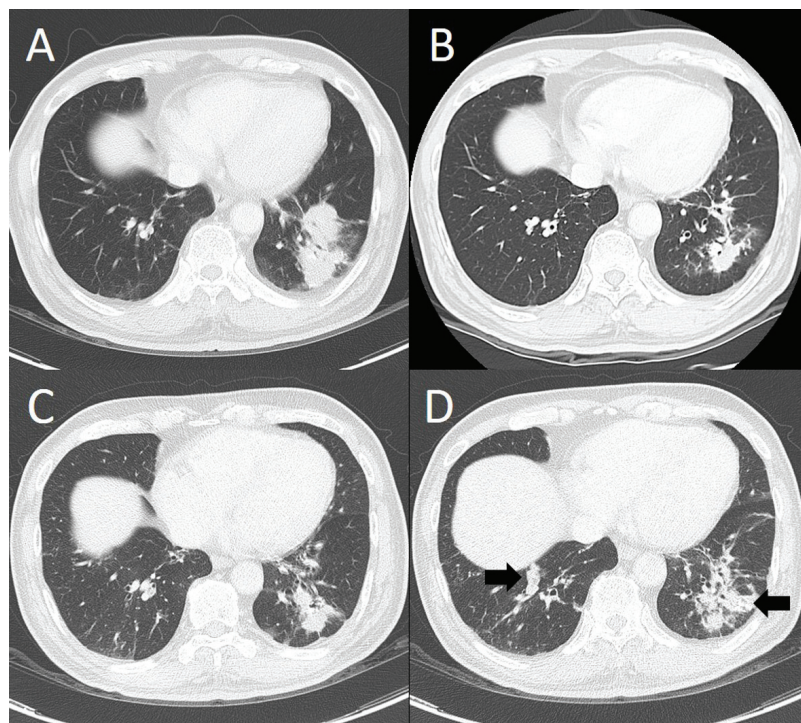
Chest CT image showing the primary tumor at the left lower lobe before (A), after 3 months (B), and after 21 months (C and D) of afatinib treatment.
